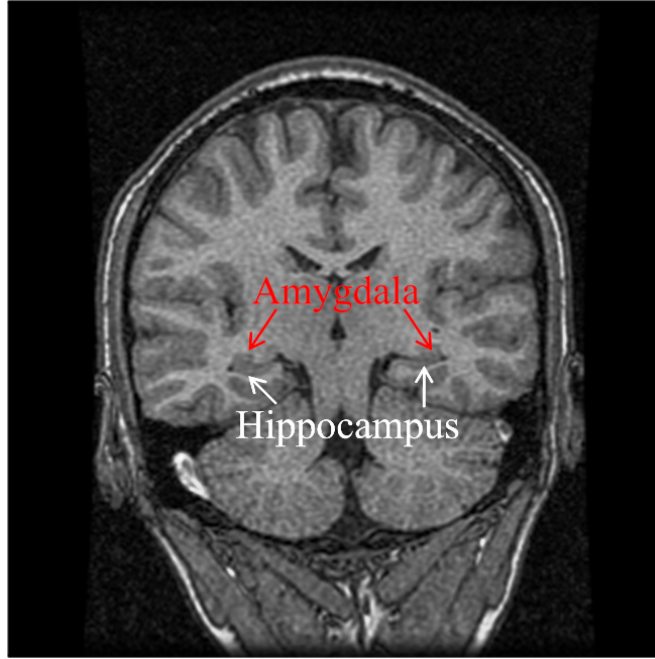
An example of a brain MR image in the coronal view, highlighting the hippocampus and the amygdala.
